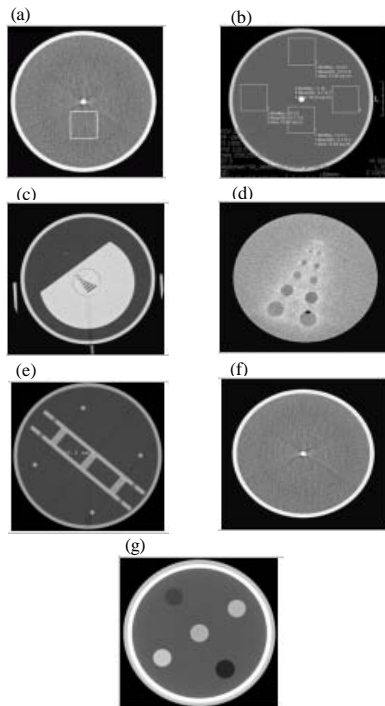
AAPM quality control images: a) Attenuated coefficient of water, noise measurement; b) Uniformity measurement; c) High contrast resolution; d) Low contrast resolution; e) Slice thickness; f) Artifacts and g) CT number of linearity
